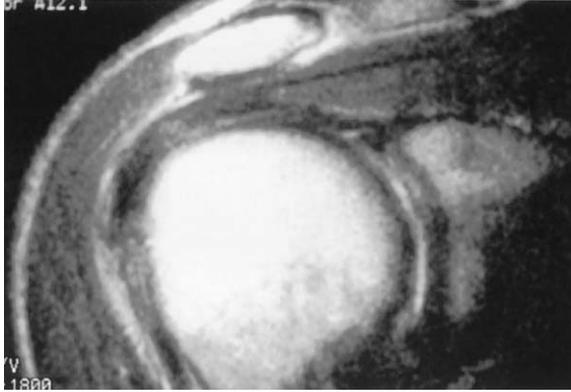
T2-weighted MRI shows increased signal in the supraspinatus tendon consistent with tendinitis.
